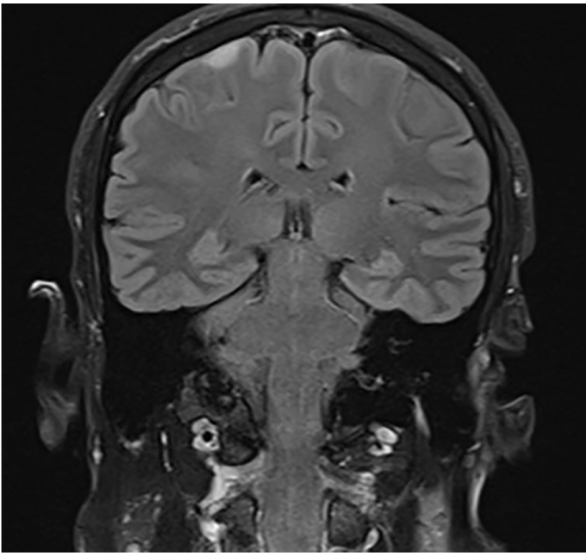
Brain MRI native axial fluid-attenuated inversion recovery on the second day of hospitalization of case no. 1 (male; age, 28 years) displayed a well-defined, hyperintense cortical and parietal lesion.
